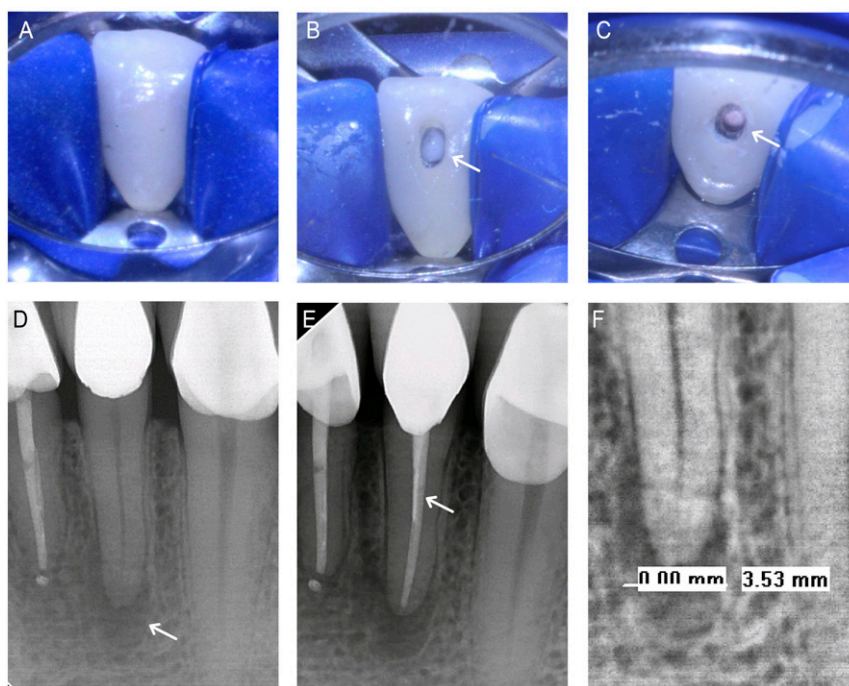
NDGP-treated patient 3 (ND3). (A) Pretreatment clinical image of tooth 23. (B) Clinical image of access cavity (white arrow). (C) Clinical image of completed obturation (white arrow). (D) Pretreatment radiograph with existing periapical lesion (white arrow). (E) Completed obturation with unmodified GP apical seal, NDGP backfill, and unmodified GP coronal seal (white arrow). (F) The 3.53-mm pretreatment lesion diameter.
